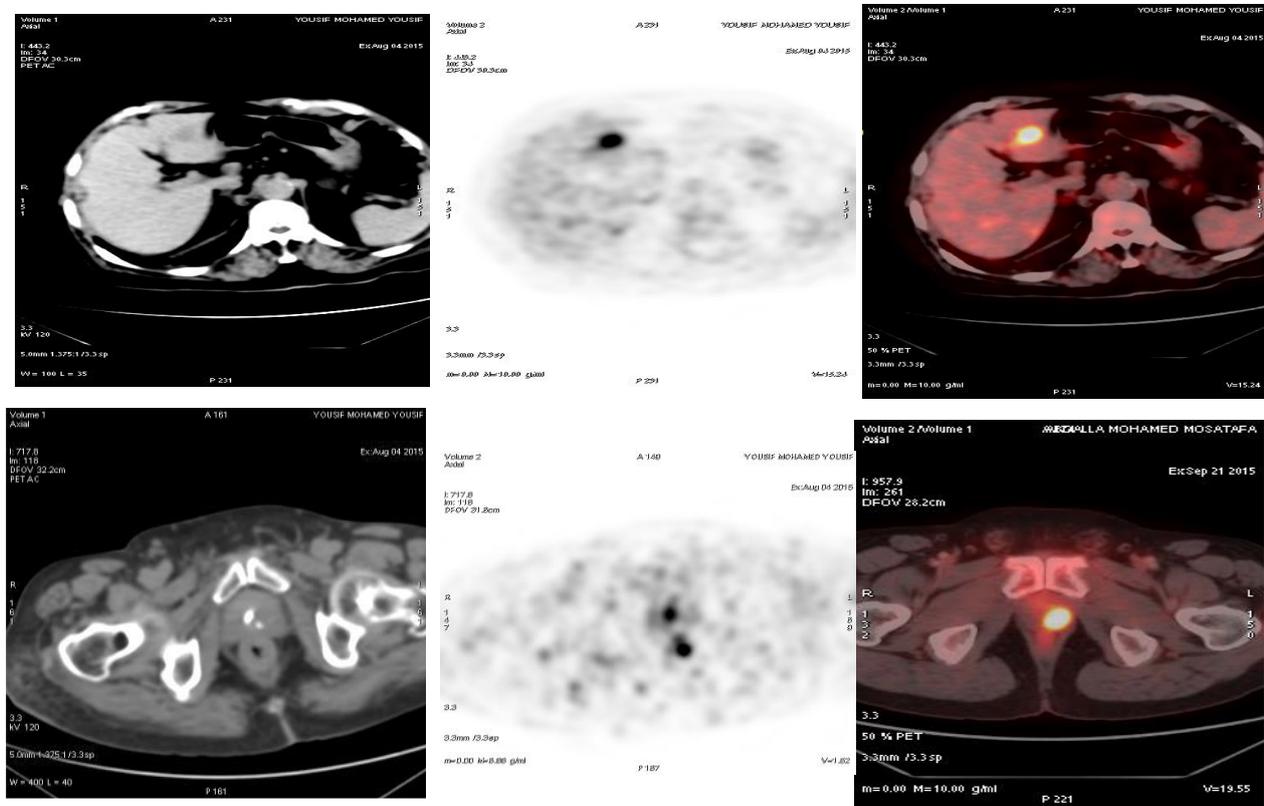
a 43 years old male patient presented by liver metastasis, PET/CT showed focal uptake at the rectal wall proved to be rectal carcinoma by after surgical excision.
